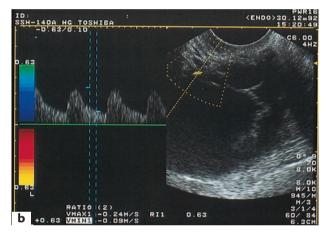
Transvaginal sonography: (a) unilocular cyst, without solid structures; (b) multilocular cyst; (c) cyst with thick septa and irregular solid parts suspected to be malignant
